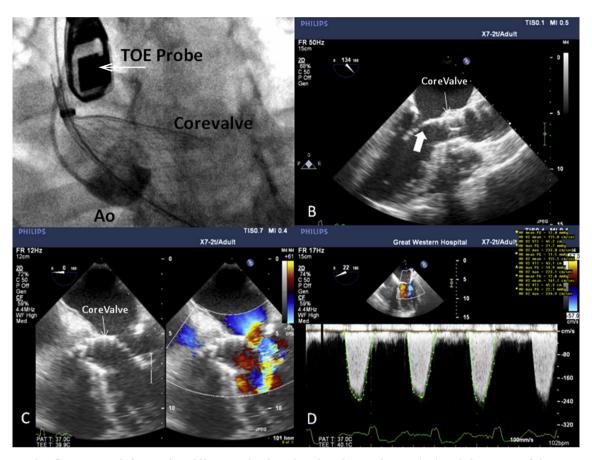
Panel A fluoroscopy left anterior oblique projection showing the aortic root (Ao) and the struts of the CoreValve below the annulus of the aortic valve. TOE probe (small arrow). Panel B transoesophageal (TOE) mid oesophageal long-axis view showing CoreValve in situ and struts impinging on the anterior mitral valve leaflet (AMVL) short arrow. Panel C (12 month follow-up) TOE modified mid oesophageal 4 chamber view showing CoreValve struts impinging on a AMVL (left) and color flow Doppler showing a high velocity jet through the restricted mitral valve in diastole (right). Panel D (12 month follow-up) continuous wave Doppler through mitral valve showing severe mitral stenosis (Peak gradient 19 mmHg and mean gradient 12 mmHg).
